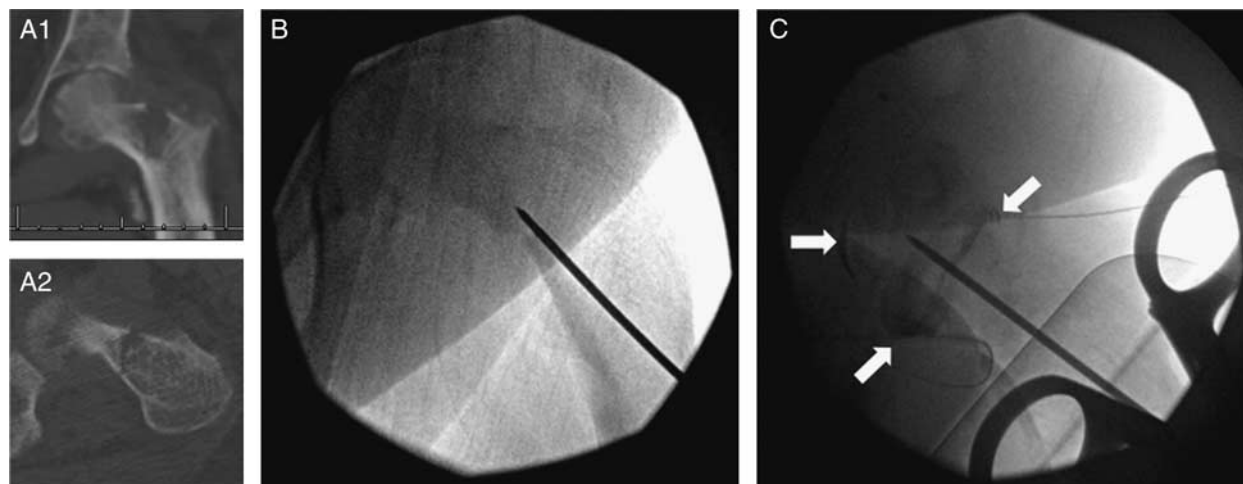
Coronal (A1) and axial (A2) computed tomographic images confirming the presence of a left neck of femur fracture. B, Appearance on initial intraoperative fluoroscopy. C, Delineation of the femoral head landmarks after arthrogram (white arrows).
